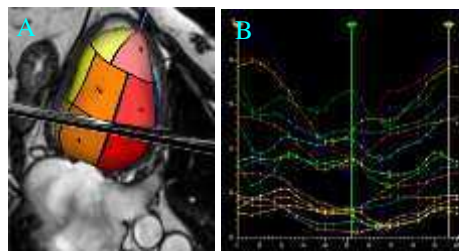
(A) 16 segment AHA model generated from whole heart MR image data. (B) 4D LV mechanical delay motion curves.
